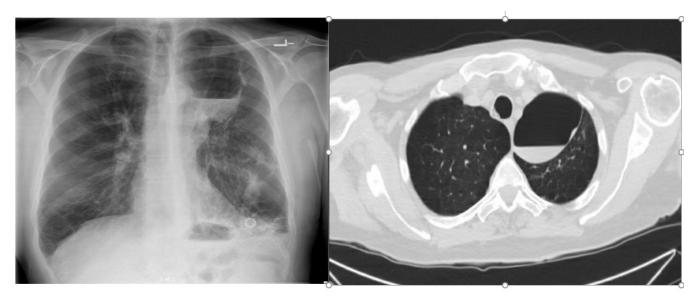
Chest X-Ray with thin-walled cavitary lesion with an air fluid level and Chest CT with a partially fluid filled bulla in the left upper lobe.
